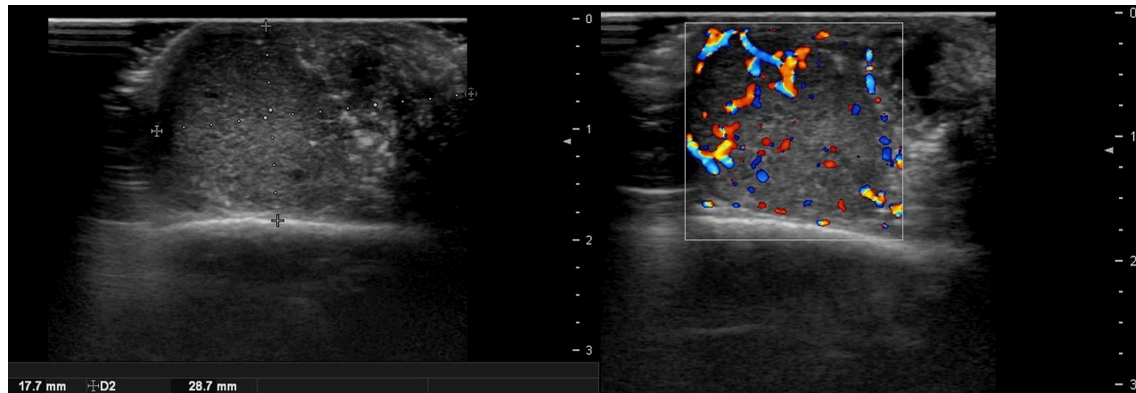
Ultrasound image of malignant proliferating trichilemmal tumor.
